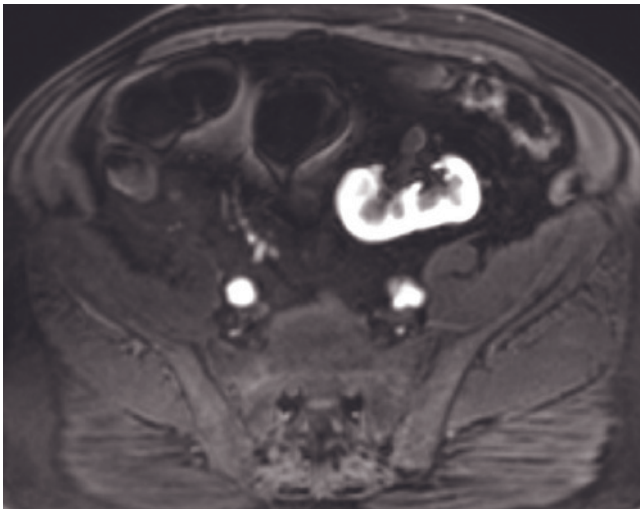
Pelvic kidney. T1-weighted immediate postgadolinium SGE image (a). The presence of corticomedullary differentiation identifies the pelvic mass as a kidney. Transverse (b) and sagittal (c) T1-weighted gadolinium-enhanced fat-suppressed
